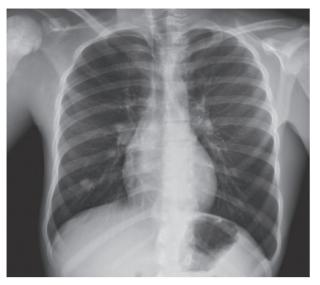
Chest radiography with suspected metastatic lesions.
